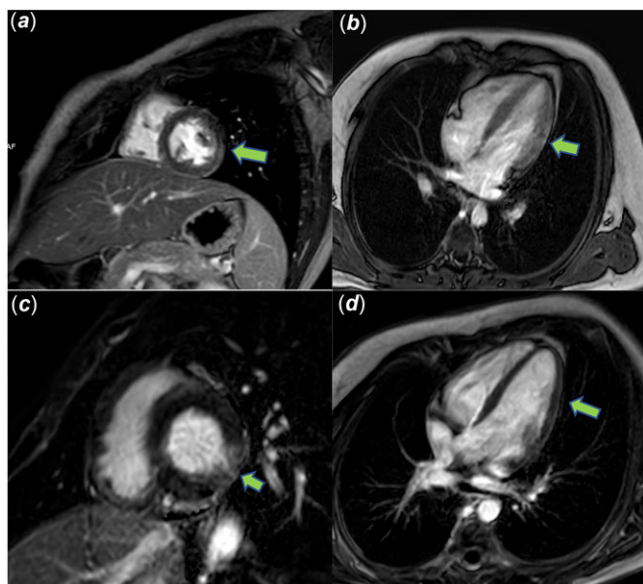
Late gadolinium enhancement, cardiac magnetic resonance images in MIS-C cases. (a) Left ventricular free wall (b) Left ventricular free wall lateral-basal area (c) Left ventricular lateral-basal area (d) Lateral subepicardial left ventricular wall (green arrows).
